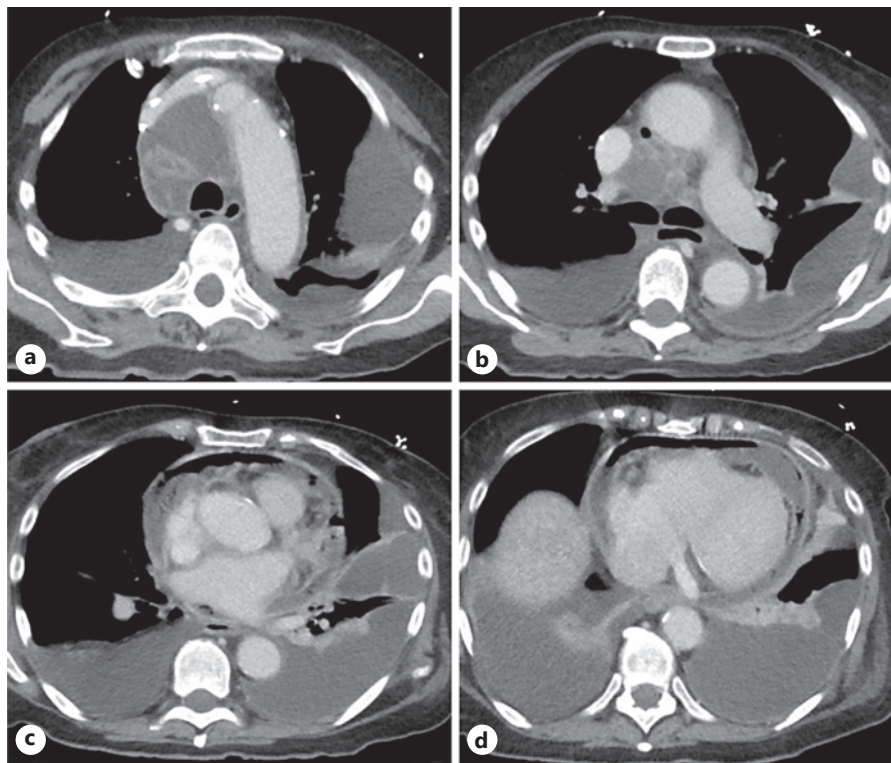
a High-resolution computed tomography (HRCT) of the chest at the level of the aortic arch demonstrating large loculated fluid collection within the mediastinum. The necrotic station 4R appeared indistinguishable from the collection. b HRCT of the chest at the level of the carina with visible mediastinal gas and loculations. c HRCT of the chest showing multiple internal locules of gas within the pericardial effusion. d HRCT of the lower chest demonstrating pericardial thickening and bilateral pleural effusions.
